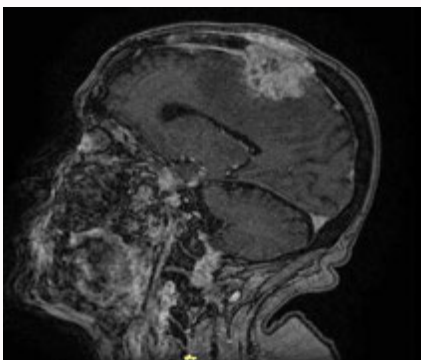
Case 2: MRI Siemens MAGNETOM SKYRA 3-T examination revealed an extra-axial mass sited in correspondence with left frontal motor convexity, that seemed adherent to the dura mater with bone erosion, suggestive for frontal meningioma.
